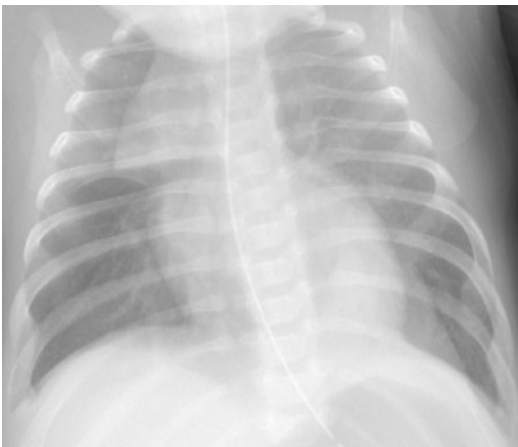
Normal gently lobulated thymic contour on chest radiograph, conforming to the overlying ribs. Note also the added left lower lobe density in this example—a sequestration
